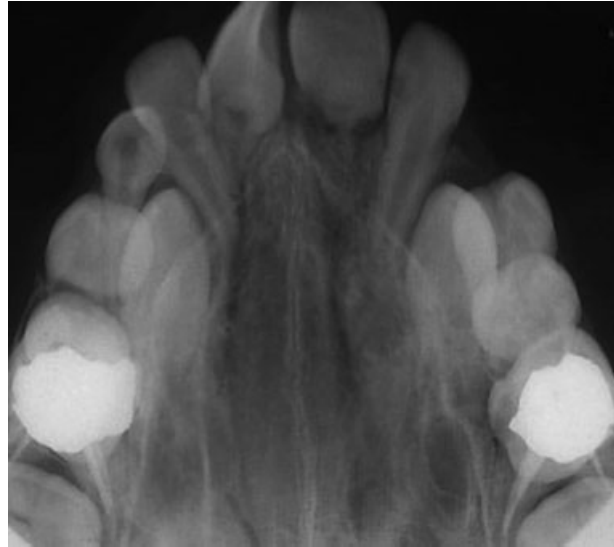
Occlusal radiograph.
